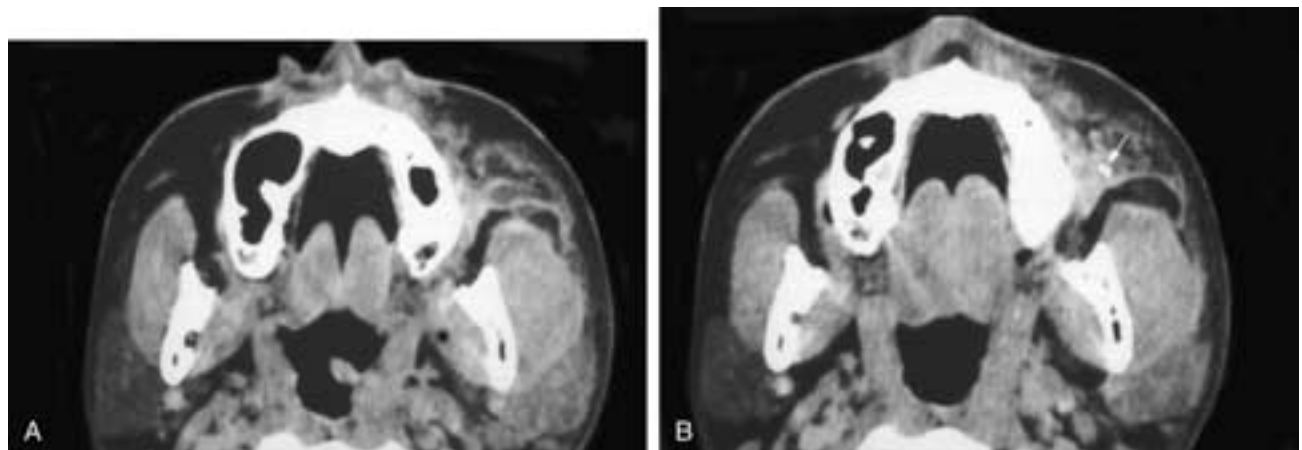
Axial CT scans (A, B) show increased density in the left parotid gland, thickening of the left masseter muscle, and increased density in the buccal fat pad region. There is also cellulitis in the overlying soft tissues in this patient with normal plane films of this region. In B, a more caudal scan shows a small calculus (*arrow*) in Stensen's duct. This patient had sialadenitis, sialodochitis, sialolithiasis, cellulitis, and myositis.
